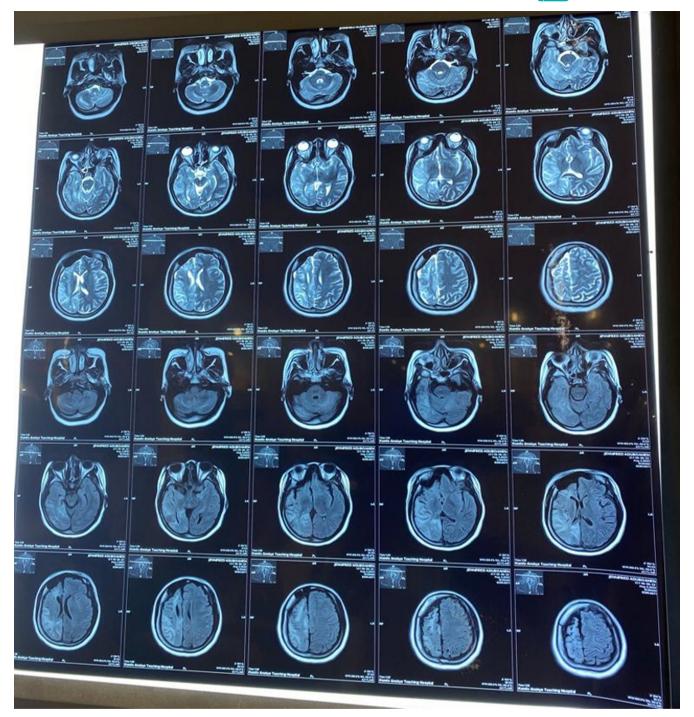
The MRI of the brain showing a reduction in the volume of the right cerebral hemisphere. There is right calvarial thickening and atrophy of the right basal ganglia.
